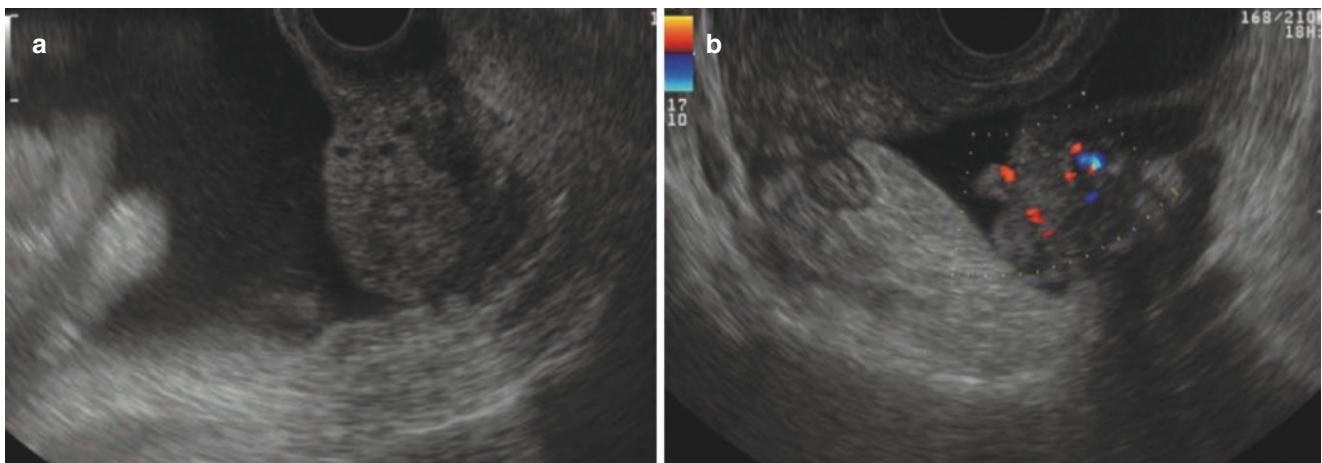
Ovarian malignant tumors (III). (a, b) A 62-year-old patient with a postmenopausal period of 8 years, represented with abdominal distention. Ultrasonography reveals a large amount of ascites in pelvic
